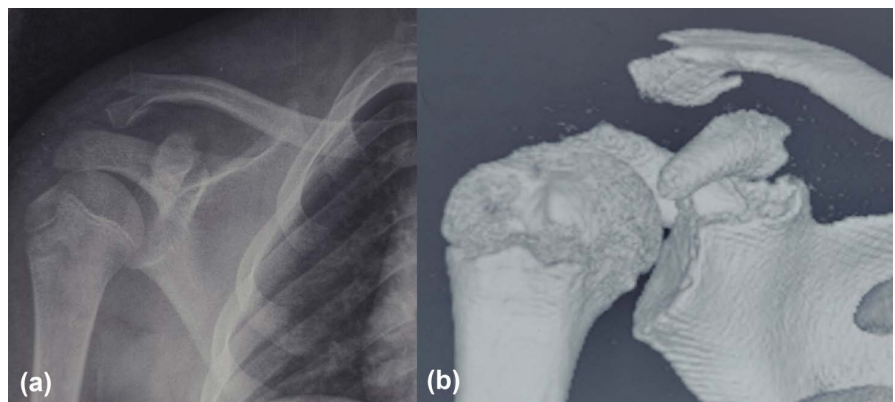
Antero-posterior X-ray (a) showing a fracture of the end of the clavicle with the fracture of coracoid process confirmed in the 3D reconstruction of CT-scan (b).
